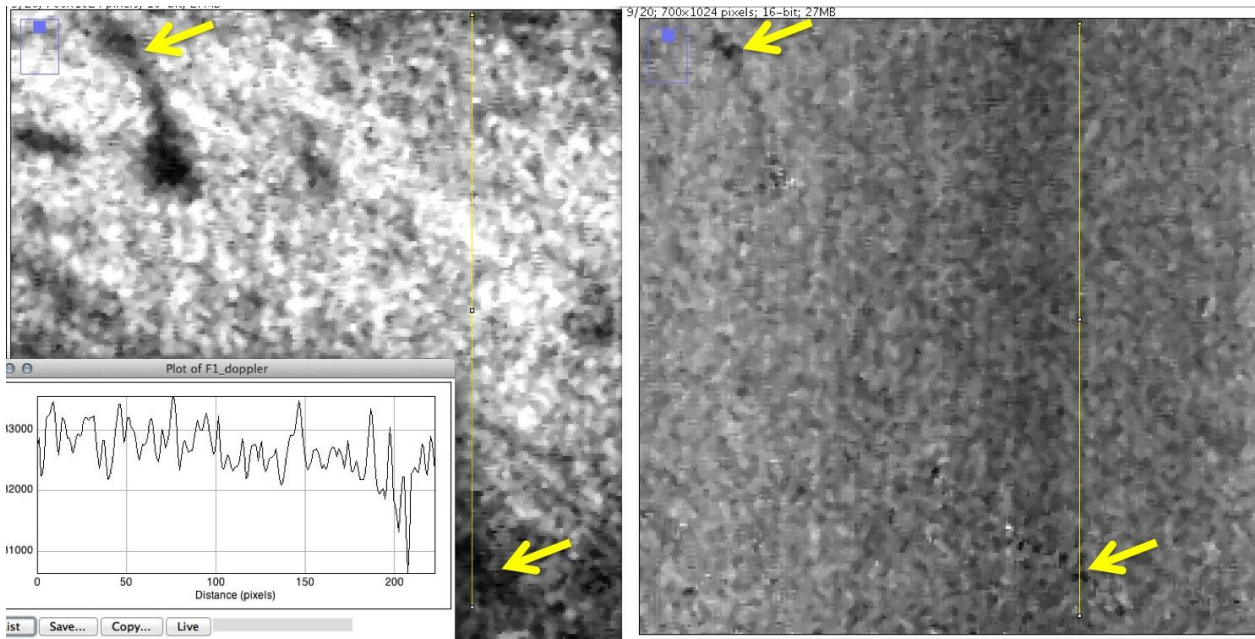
Another slice displayed two regions of small negative Doppler with signals of a similarly small magnitude.
